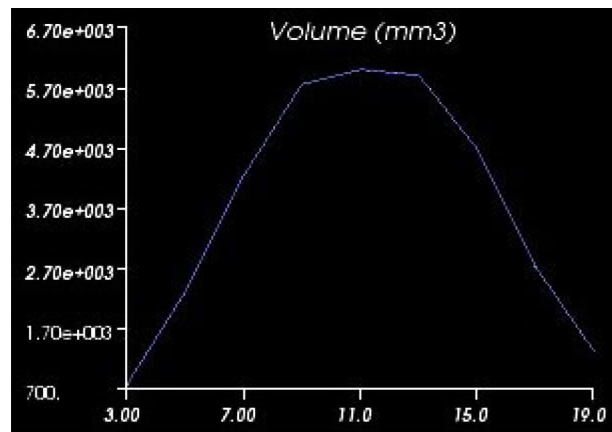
Tumor completely measured. Volume of each MRI slice of a tumor (y axis) against the slice number (x axis).
